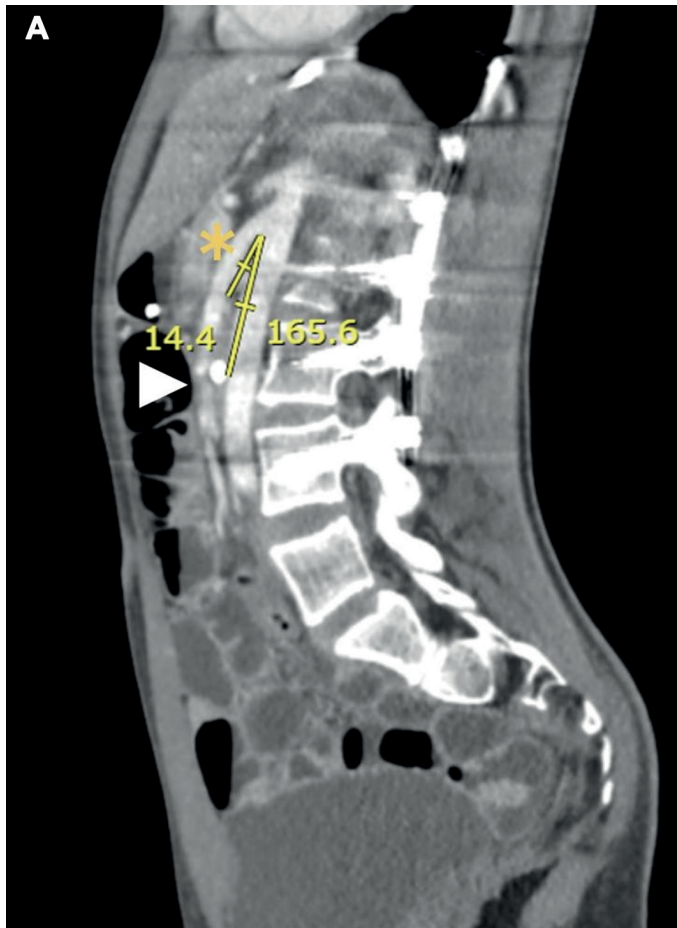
CT with Enteroclysis protocol. A. Sagittal view, B. Axial view. Yellow asterisk: SMA White triangle: third portion of duodenum with nasogastric feeding tube in lumen.
